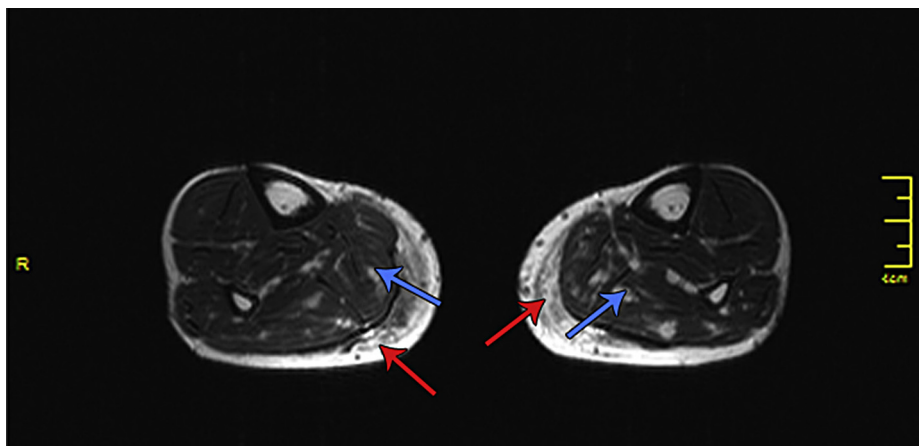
Magnetic resonance image of *Case 1* carried out at 12 months. The presence of fat tissue is seen in the intra-gastrocnemius (blue arrows) and intra-soleus space (green arrows).
